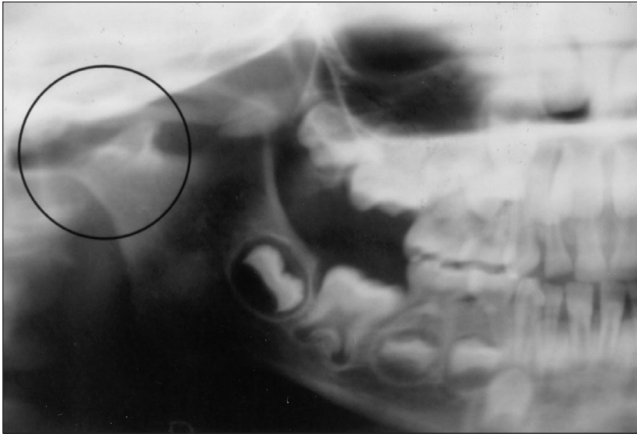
Detail of dental panoramic radiograph obtained during the initial presentation shows fracture of the right condylar head.
